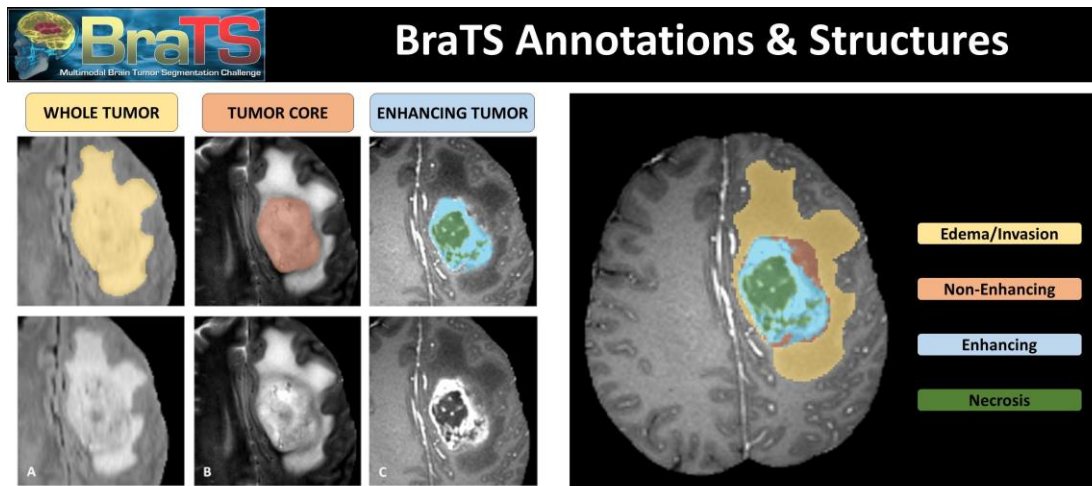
Sub-regions of glioma. In the multiple MRI modalities, image patches with tumour sub-regions annotated. From left to right, the picture patches display the whole tumour (WT - yellow) seen in T2-FLAIR (Fig. A), the tumour core (TC - orange) visible in T2 (Fig. B), the enhancing tumour (ET - light blue) evident in T1-Gd, and the cystic/necrotic components of the core (green) (Fig. C). The final labels for the tumour sub-regions (Fig. D) are edema/invasion (yellow), non-enhancing solid core (orange), necrotic/cystic core (green), and enhancing core (red) (blue). (‘Multimodal Brain Tumor Segmentation Challenge 2020: Data | CBICA | Perelman School of Medicine at the University of Pennsylvania’ n.d.)
